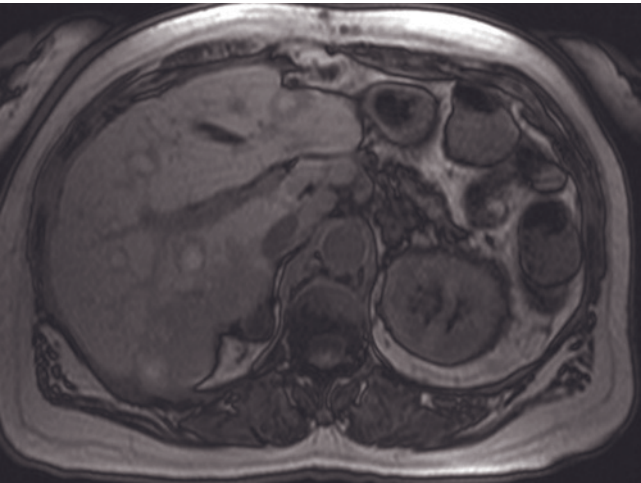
Carcinoid liver metastases. Fat-suppressed T2-weighted ETSE (a) and SGE (b) images. Metastases are heterogeneous with mixed high-signal intensity on T2 (a) and T1 (b) images. The high signal intensity on the T1-weighted image (b) reflects a high protein concentration due to protein synthesis from hormone production. The high signal on T1-weighted image (b) is an uncommon appearance for carcinoid metastases.
